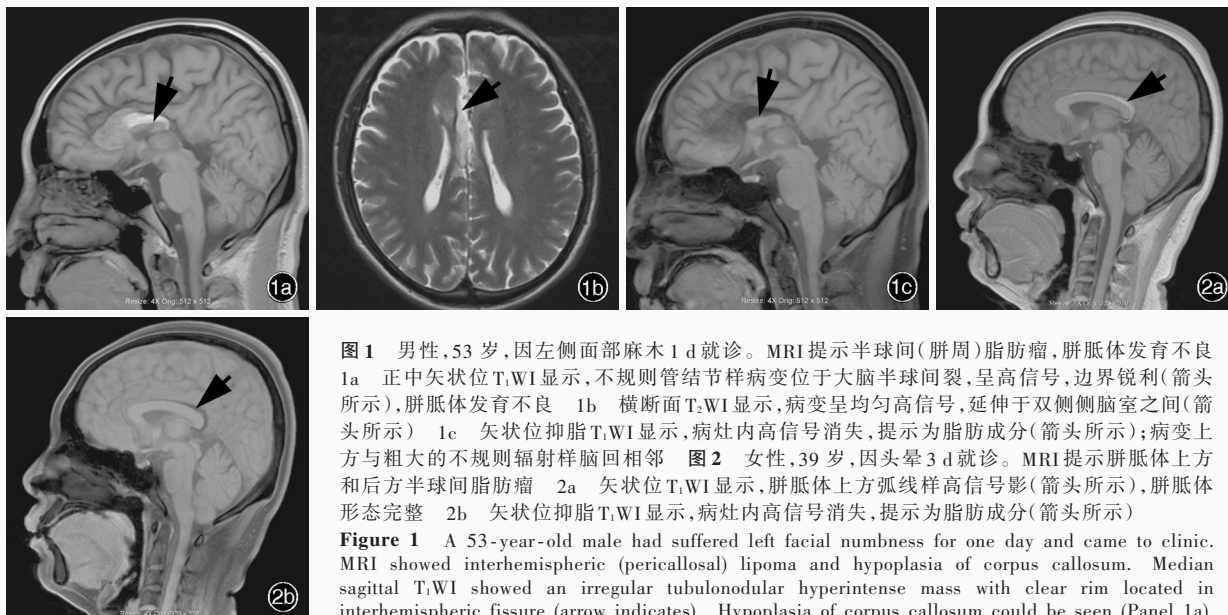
男性, 53 岁, 因左侧面部麻木 1 d 就诊。MRI 提示半球间(胼周)脂肪瘤, 胼胝体发育不良
